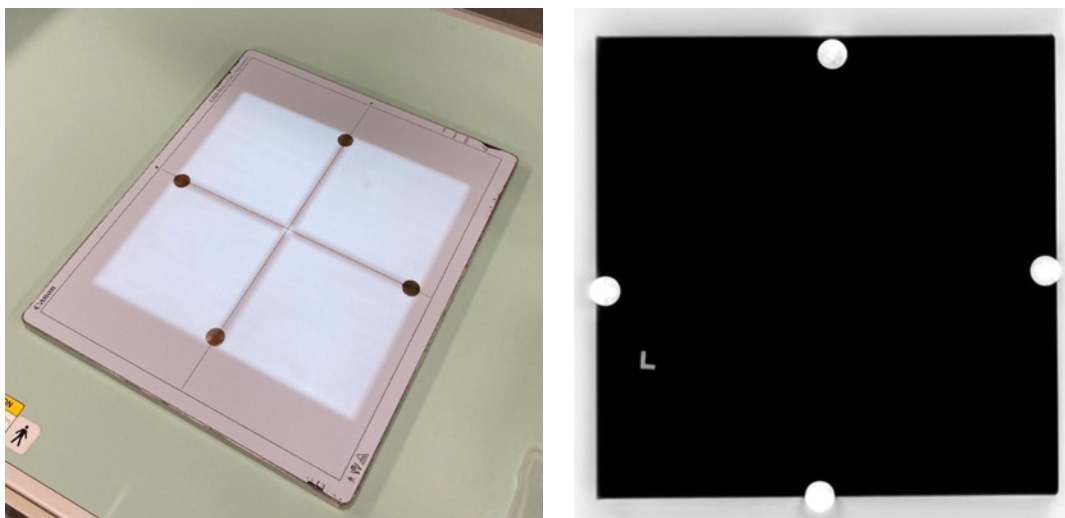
Measuring x-ray/light field alignment using coins and software distance tool.
